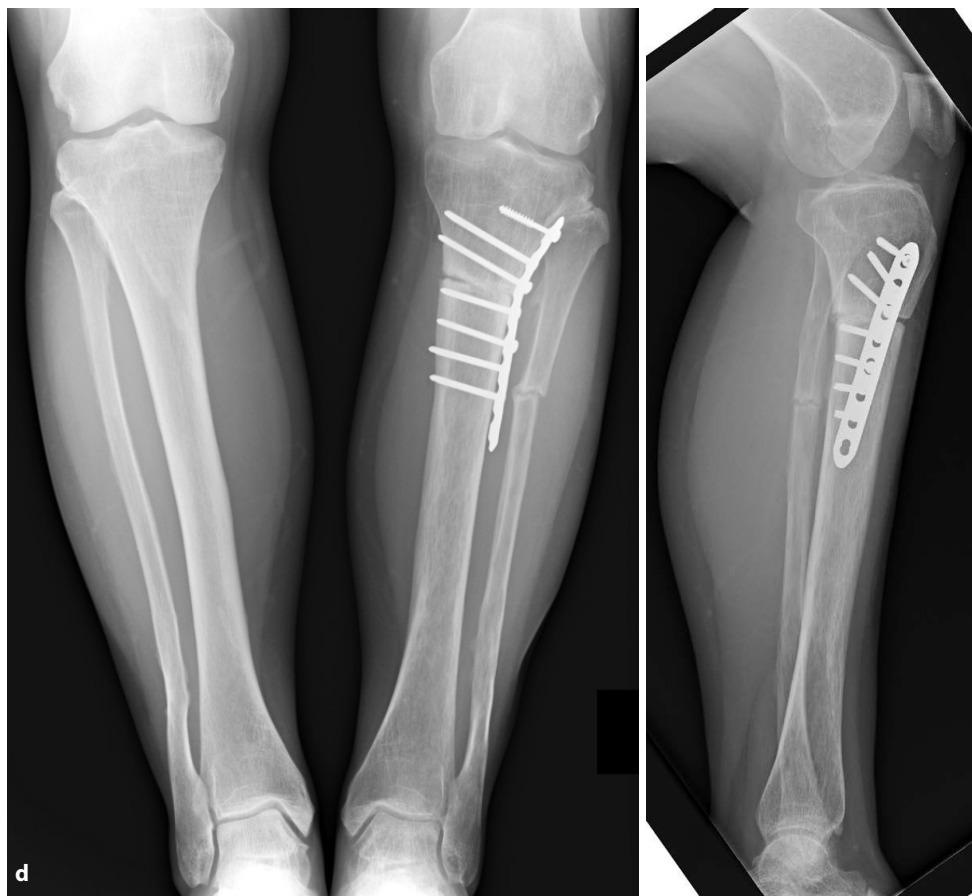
Correction and healing – remodeling of the tibia and fibula osteotomy 10 months after surgery: the LCP splint and all screws are in situ with no signs of loosening; symmetric mild varosity of both knee and talocrural joints; Radiographic evidence of moderate continued remodeling (healing) of the tibia osteotomy – compare a and b.
